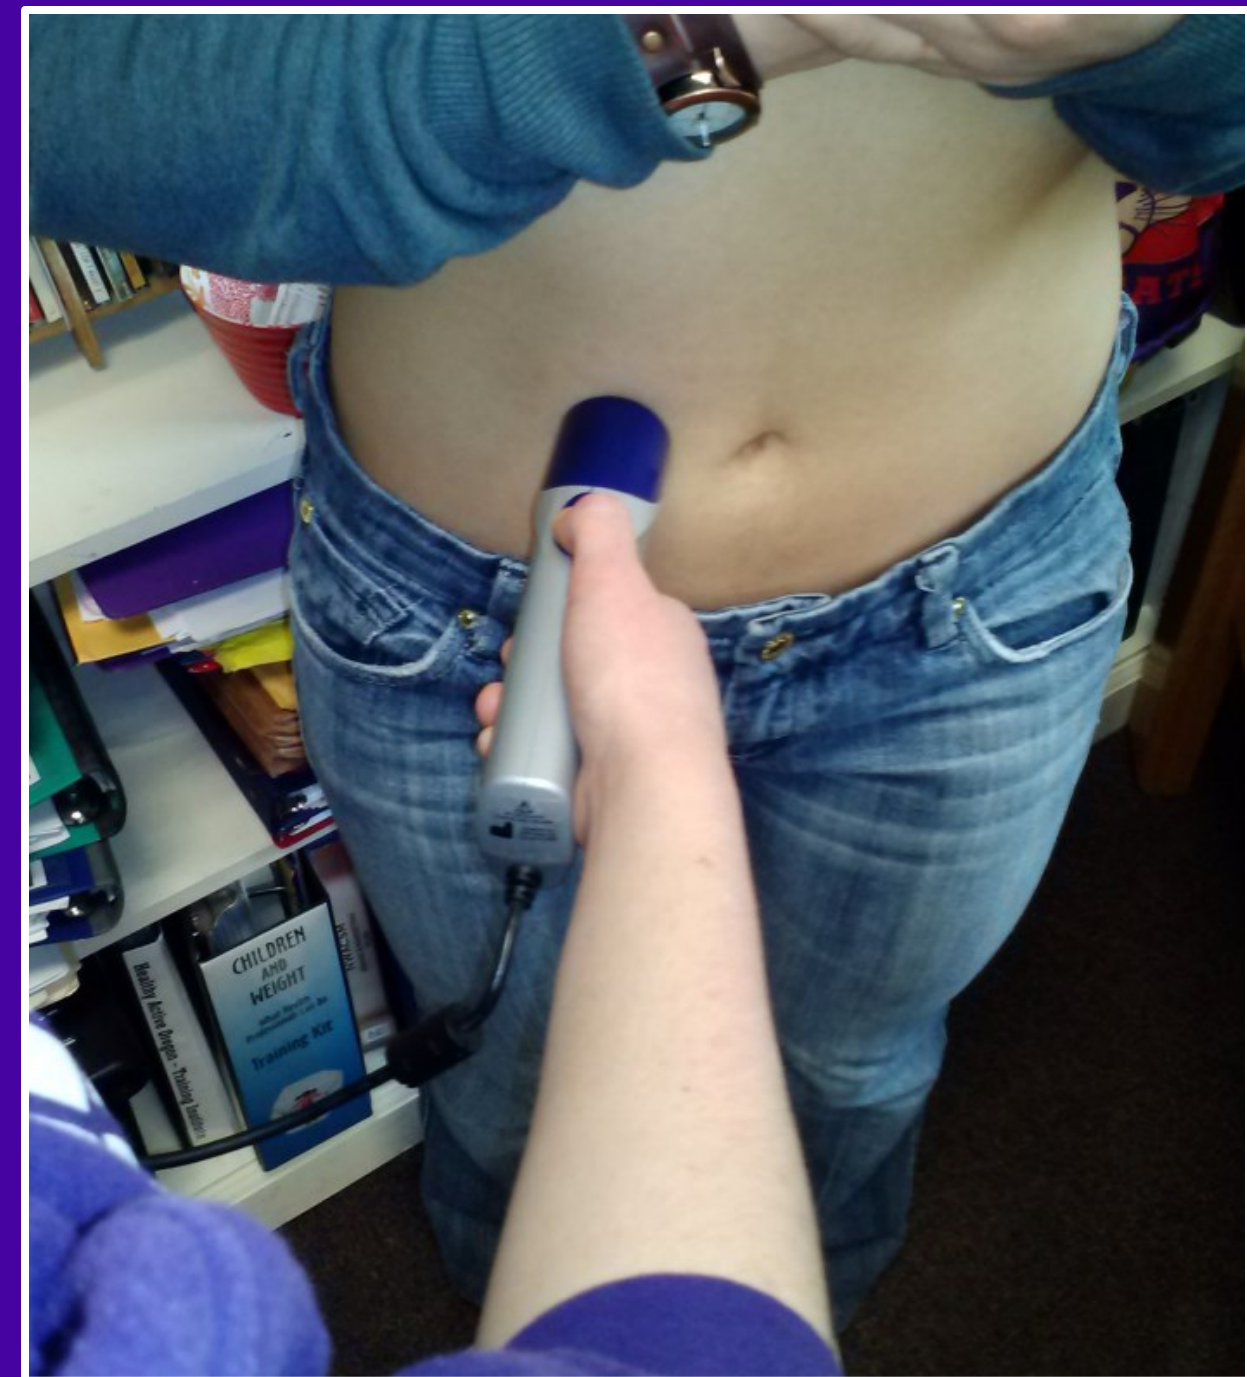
Data collection using the BodyMetrix ultrasound machine.
